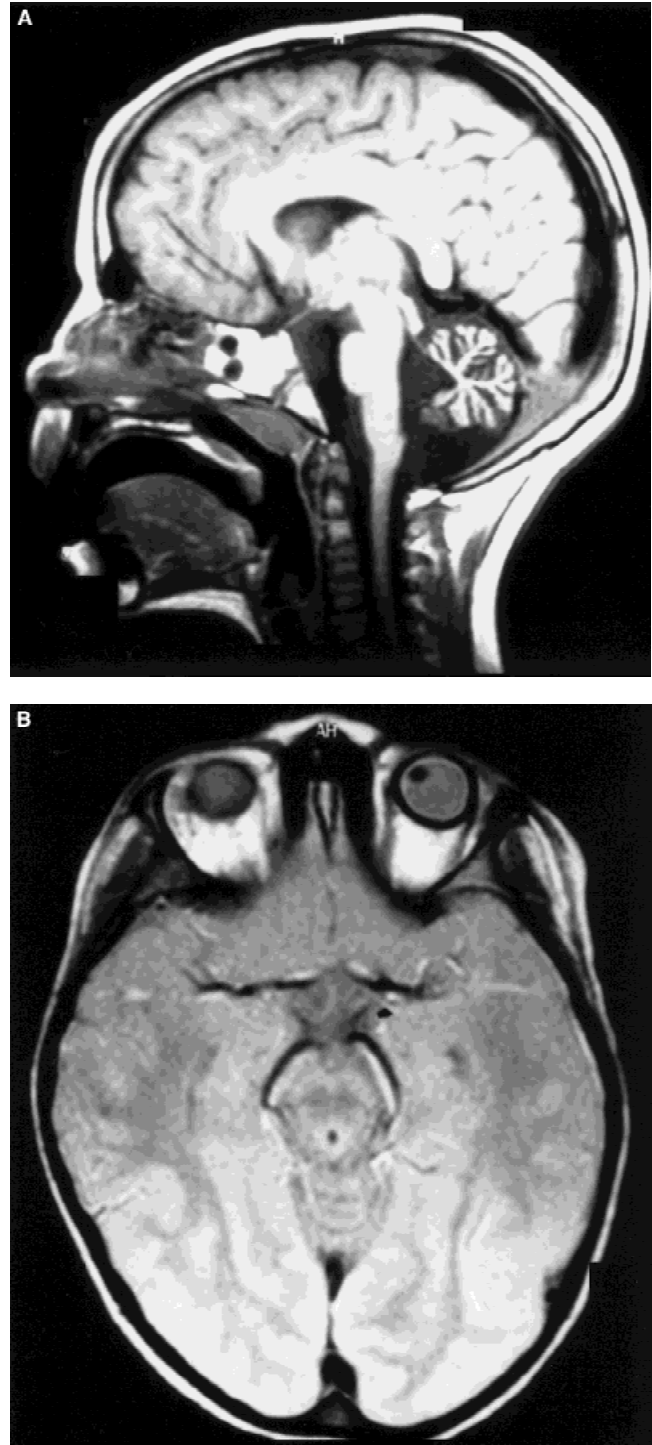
A: Spin-echo head MRI demonstrating marked cerebellar hypoplasia. B: MRI showing microphthalmia, slightly more evident in the right eye.
